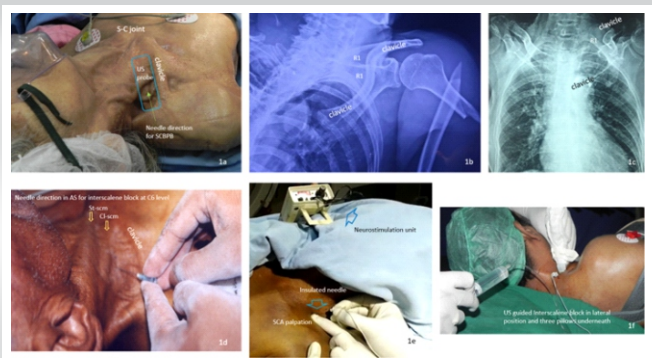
S-C = sternoclavicular joint; US-ultrasound; SCBPB-supraclavicular brachial plexus block; R1-rib; St-scm=sternal head of sternocleidomastoid; Cl-scm=Clavicular head of sternocleidomastoid;SCA=subclavian artery;
